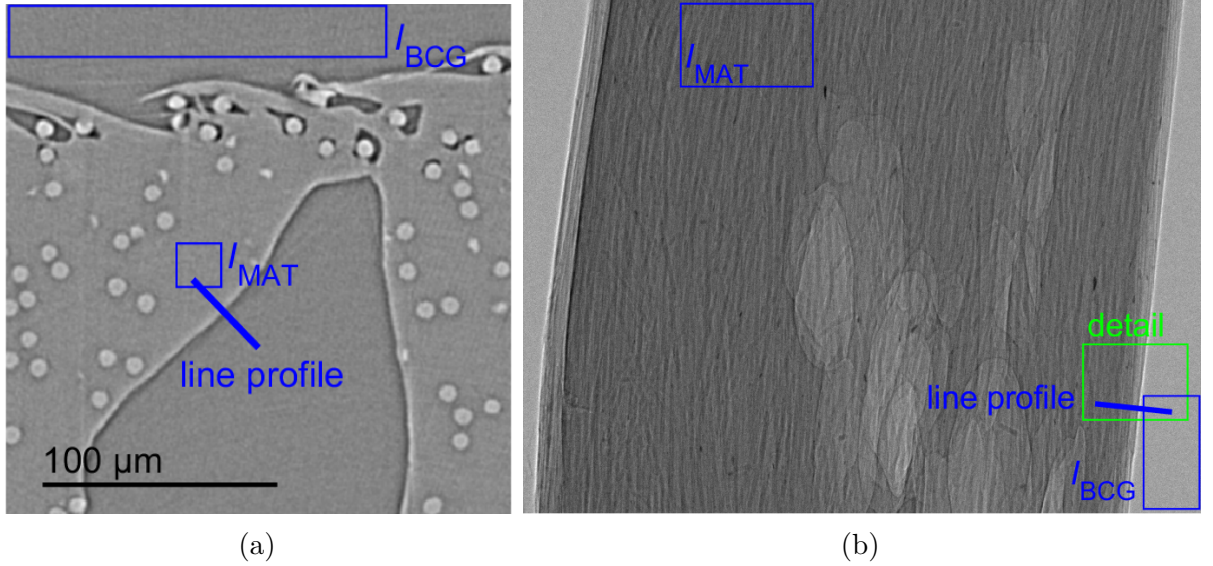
Image evaluation regions of measurements of CFRP, a) CT slice, b) projection.
